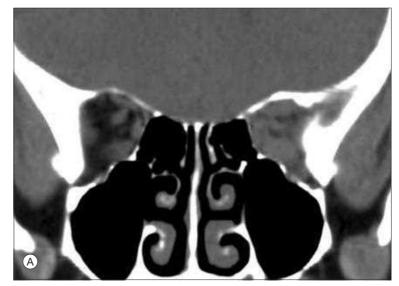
(A) Coronal CT scan showing left orbital apex optic nerve crowding from enlarged extraocular muscles. Little perineural fat is visible, and Snellen visual acuity was reduced to 6/60 in the left eye. (B) Postoperative coronal CT scan demonstrates medial wall decompression relieving pressure on optic nerve. Vision was restored to 6/6. Notice that the medial rectus muscle continued to expand following the decompression, and this may be reduced with concomitant radiotherapy. (Courtesy Dolman PJ. Evaluating graves orbitopathy. Best Pract Res Clin Endocrinol Metab 2012;26:229–48. p. 240.)
